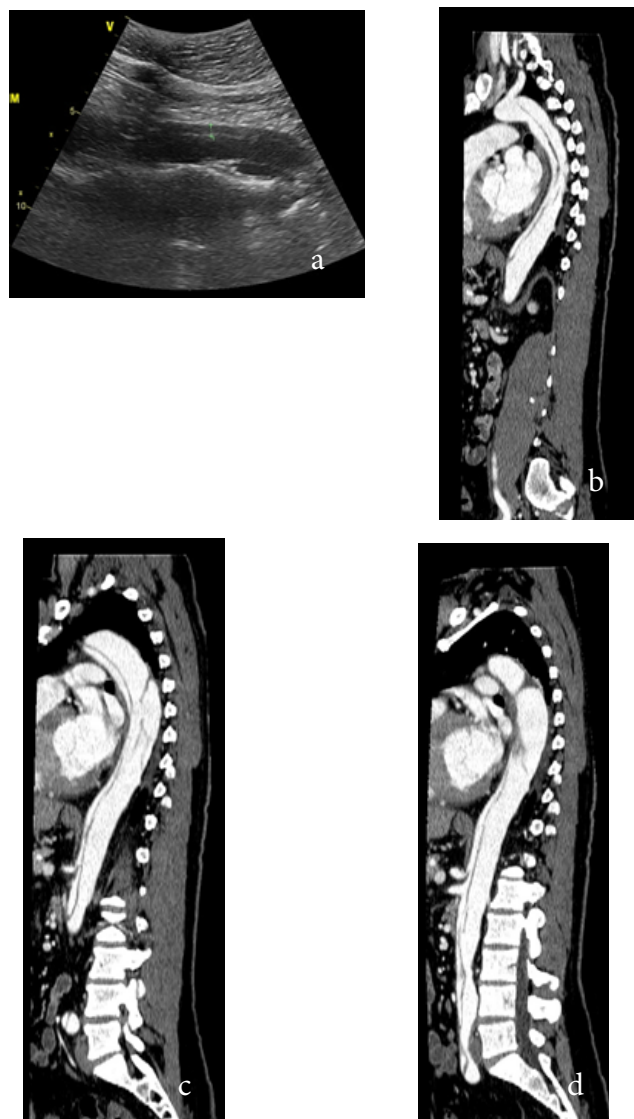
a: Abdominal vascular ultrasonography showing two intimal flaps in the abdominal aorta (head of arrow); b,c,d: coronal reconstruction abdominal aortic angiography images shows many intimas' flaps (dark lines) with true lumen anteriorly and false lumen is posteriorly, extending to iliac arteries.
